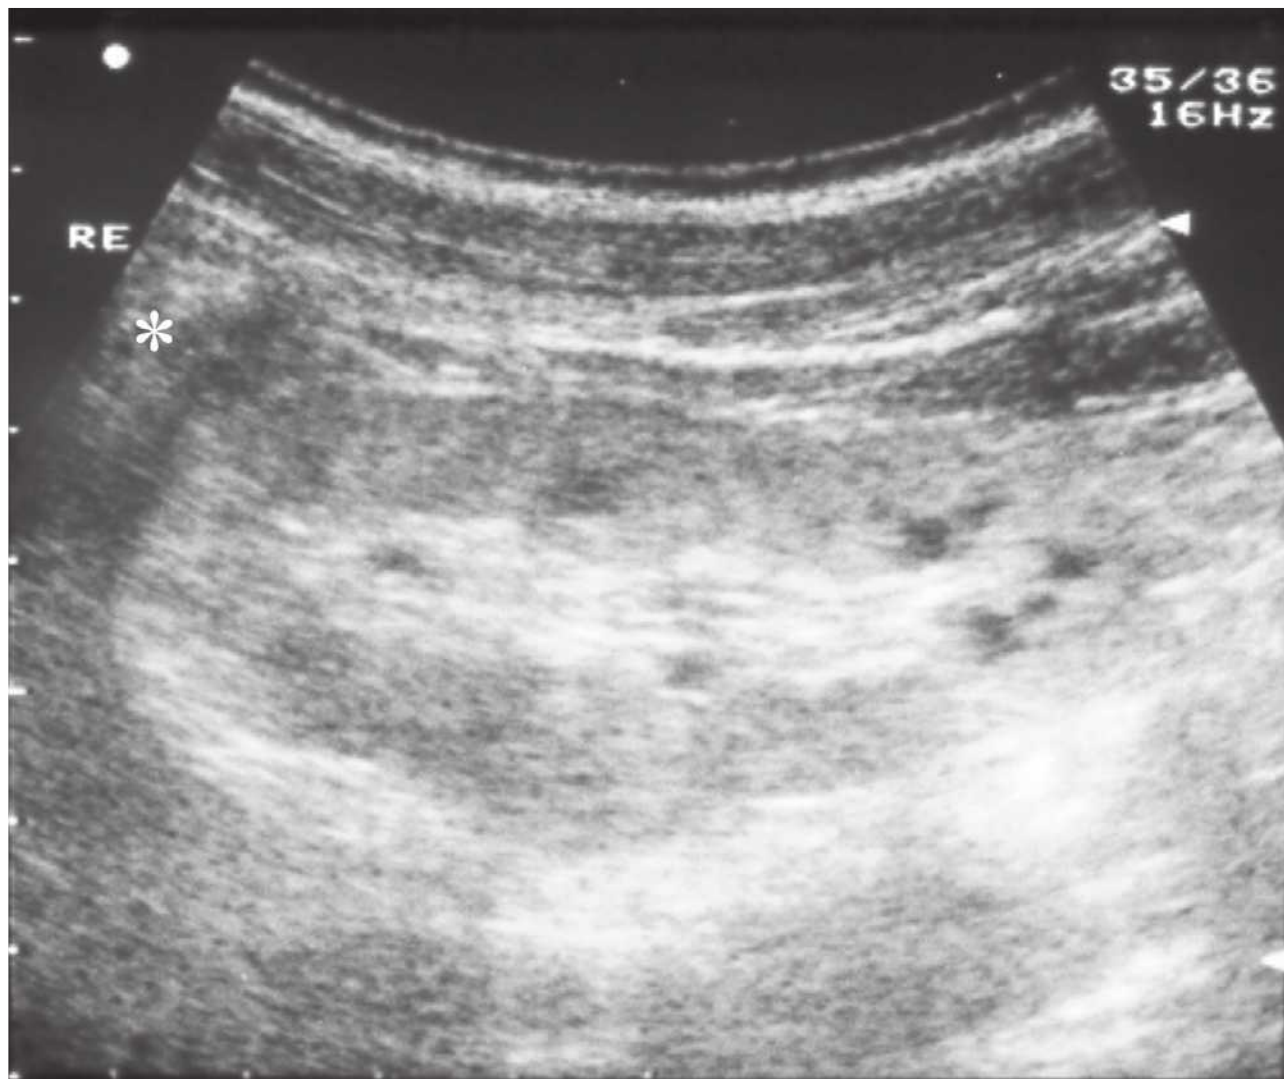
Characteristic renal ultrasound findings in juvenile nephronophthisis (NPHP1). Note the normal kidney size, the loss of corticomedullary differentiation, and the increased echogenicity, which renders the pattern of the kidney similar to that of the liver (*), together with the presence of cysts at the corticomedullary border of the kidney. (Courtesy of Prof. J. Dippel, Frankfurt, Germany.)
